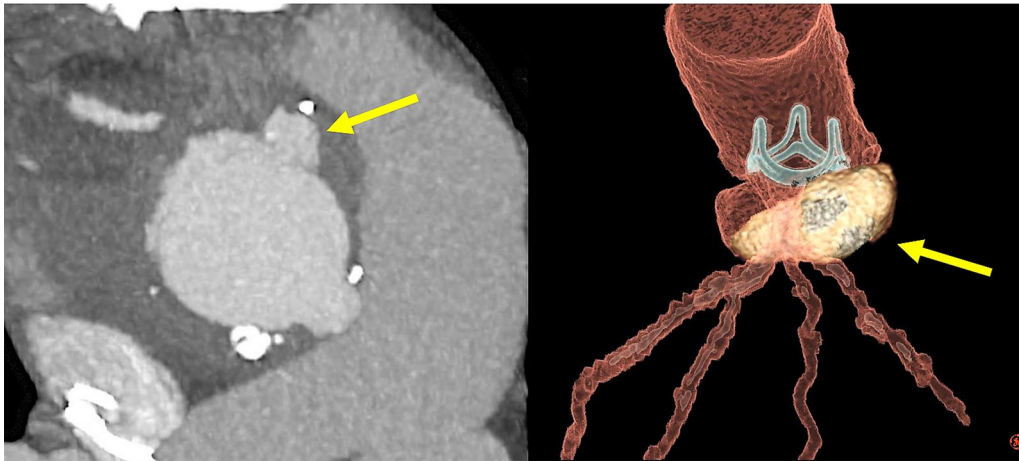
Aortic root abscess. Left: axial computed tomographic image showing the aortic root abscess. Right: a 3D volume rendered image of prosthetic valve endocarditis showing extensive root abscess.
